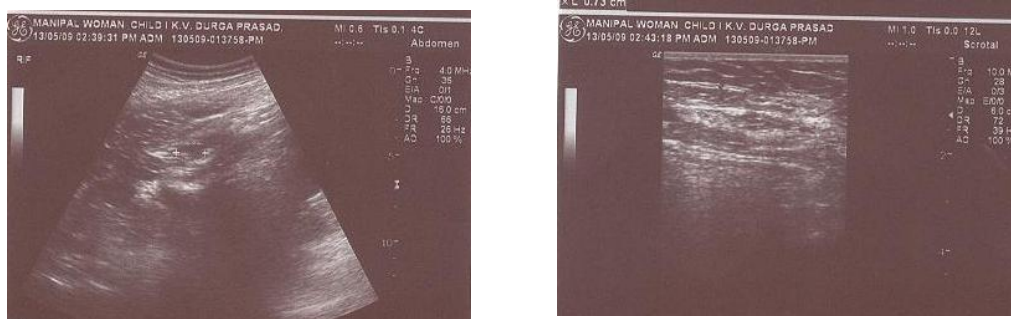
Ultrasound of the abdominal cavity showing undescended testis.
